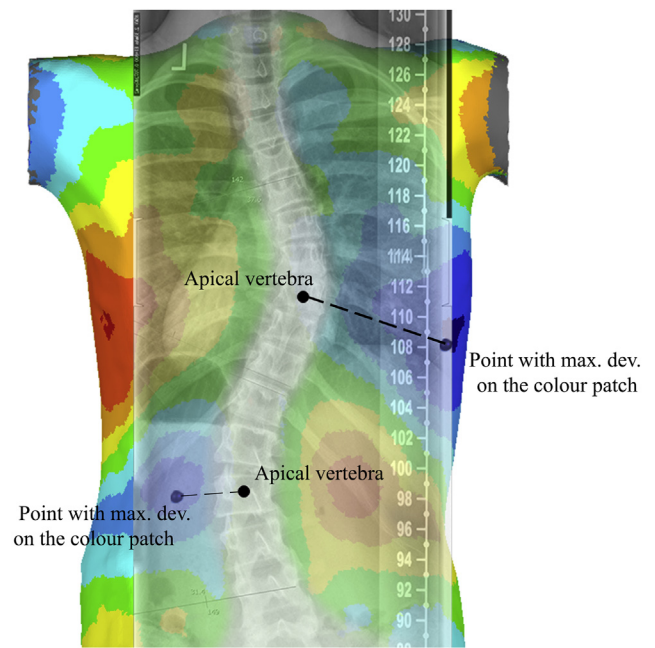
The deviation color map of a patient with AIS with superimposed corresponding x-ray.
